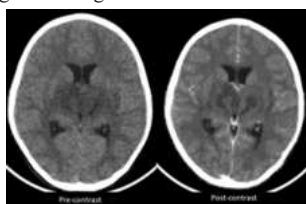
Case of a 34-year-old male patient with Japanese Encephalitis, CT shows enlarged bilateral thalami with central hypodensity (pre-contrast HU: 12) and no contrast uptake (post-contrast HU: 12.8) in comparison to the periphery (HU: 20).
